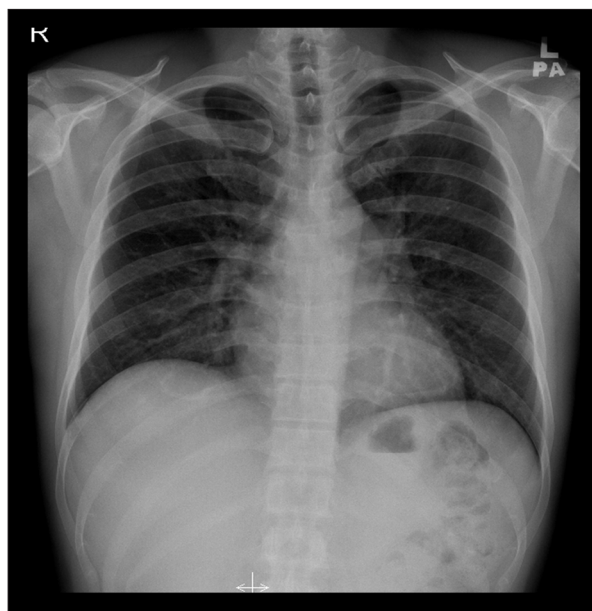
Chest X-Ray on June 30, 2020, showed clear lung fields with no mediastinal widening or hilar lesion.
